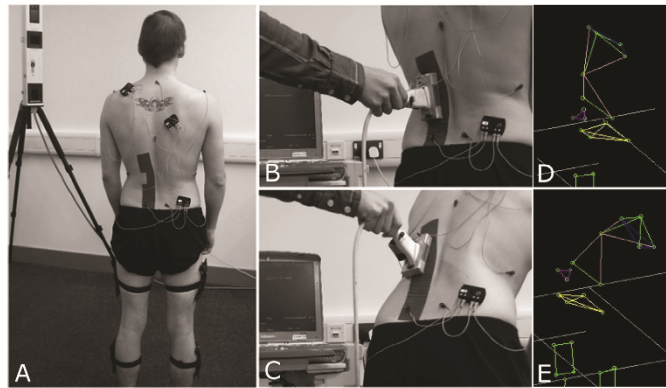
Demonstration of KT application and data collection. A: KT application with cut-out, and motion capture marker positions. B&C: ultrasound scanning during movement; the probe head was attached with a frame and 3 motion markers. D&E: examples of stick figures in the motion capture system.
